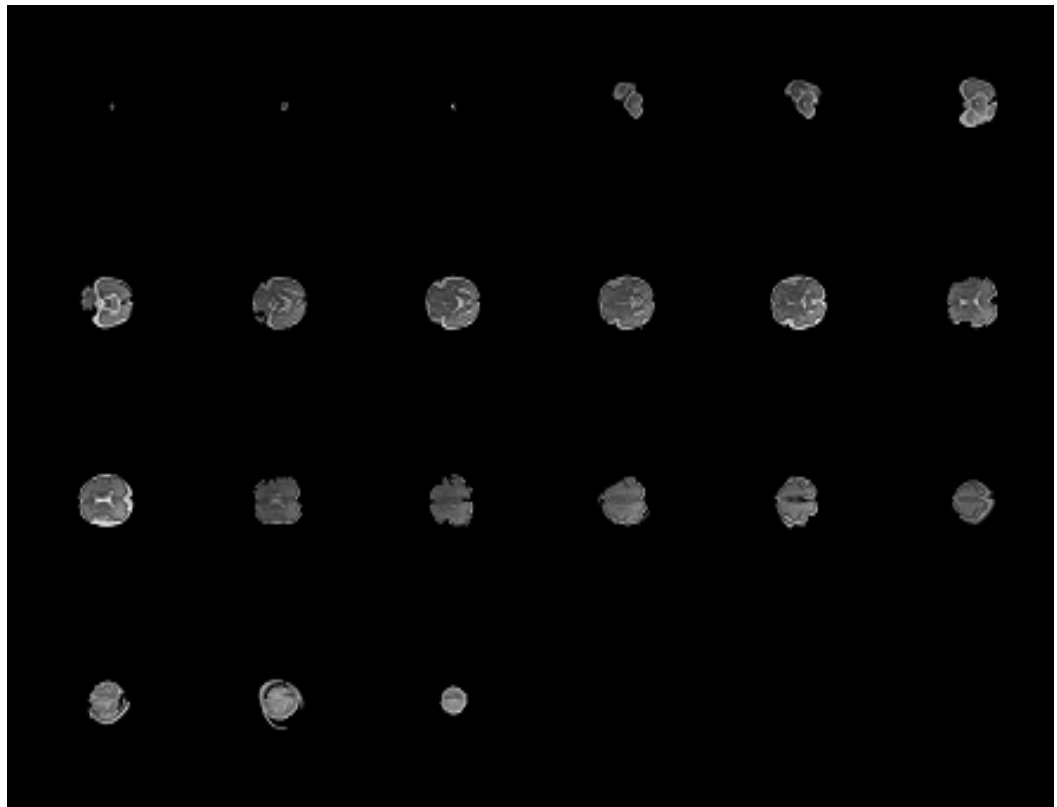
Fetal abnormal brain MRI (GW 29)
